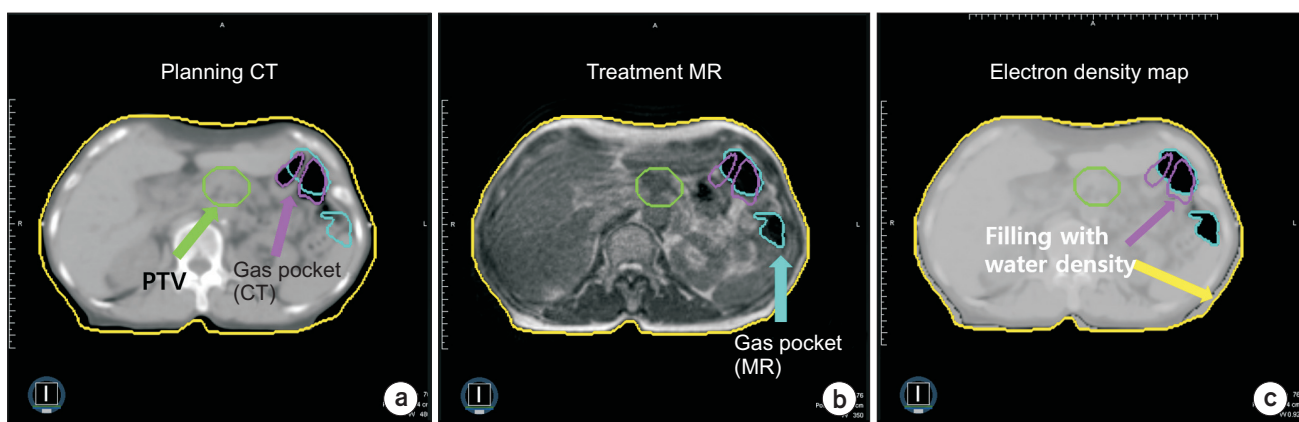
Example of a modified electron density map. (a) The original planning computed tomography (CT) with the air pockets are indicated in purple. (b) Daily treatment magnetic resonance (MR) images were re-contoured at air pockets and the body, shown in blue and yellow, respectively. (c) The electron density, modified according to the variation of the air pockets and body outline. PTV, planning target volume
